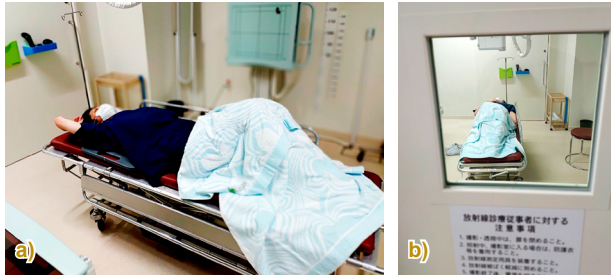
Patient condition at the time the chest X-ray image in Fig. 2 a) was obtained (recreated). From the observation window, it was not possible to grasp the whole situation (right).
